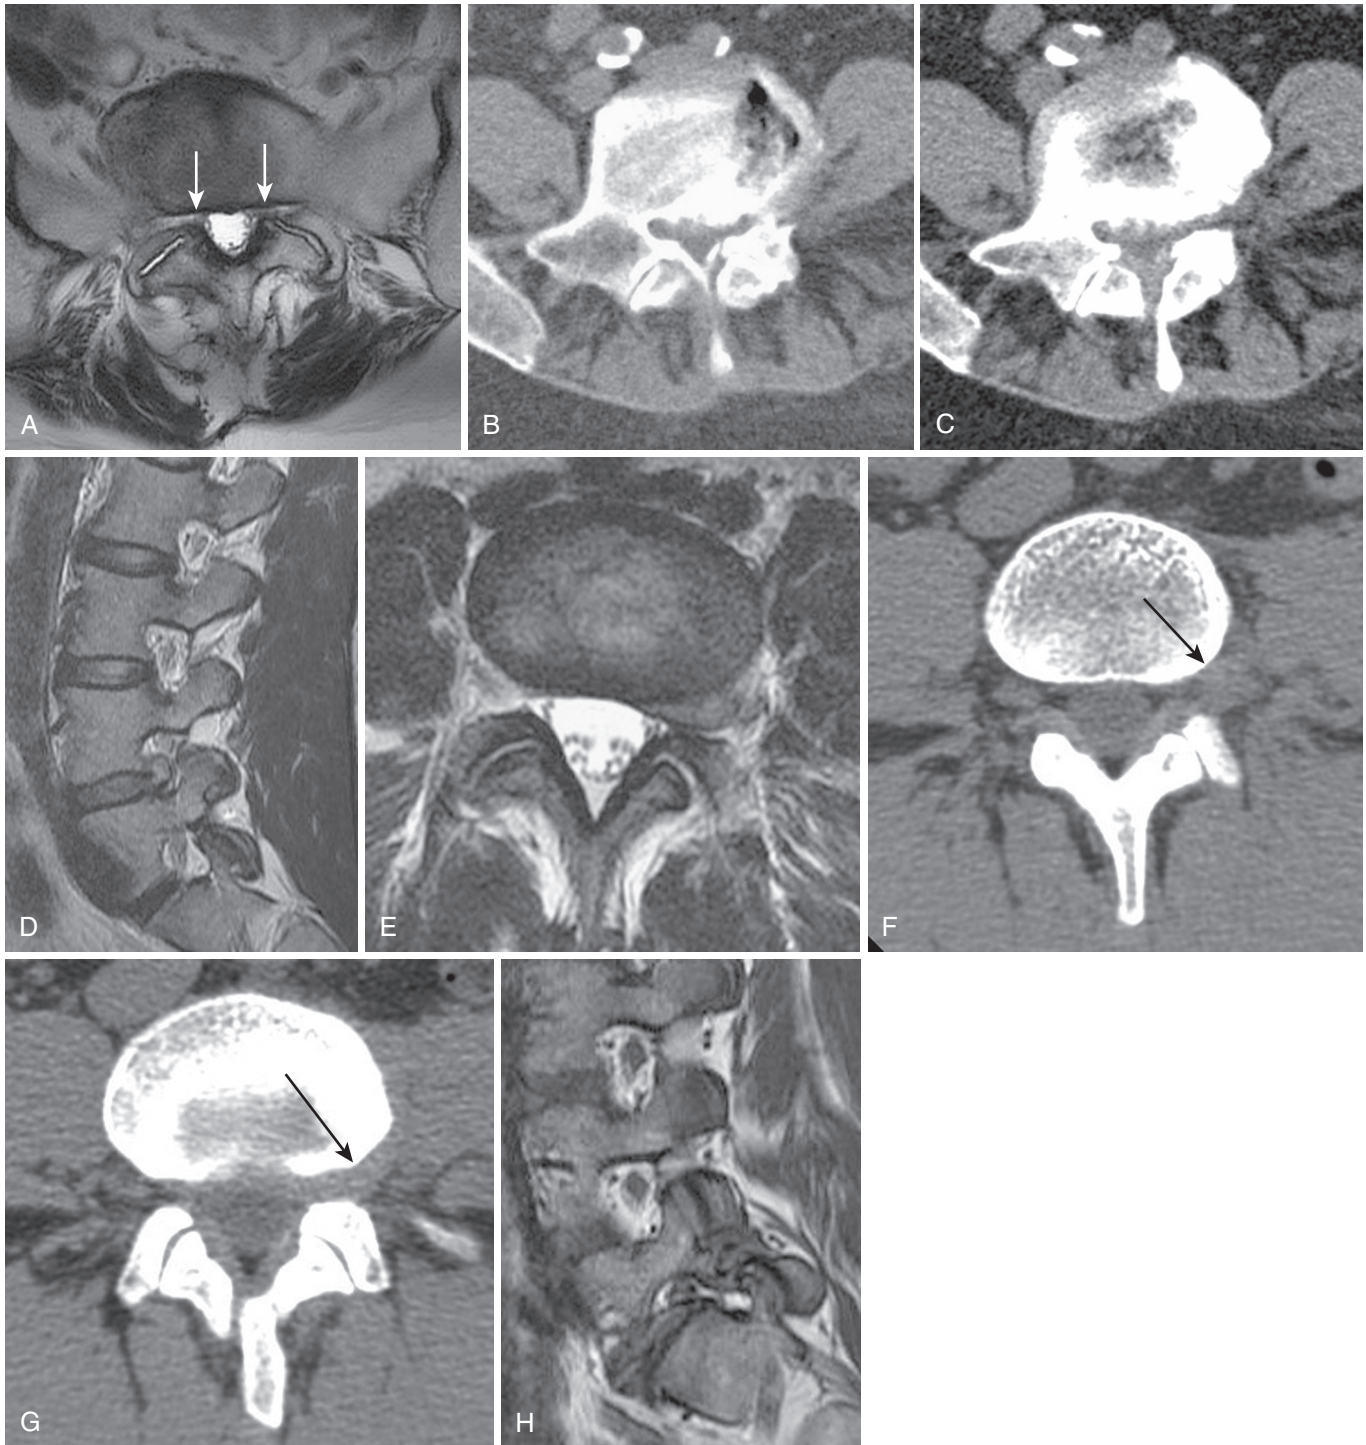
Subarticular zone (lateral recess) and foraminal compromise. Axial T2 MRI image (A) at the S1 superior end plate demonstrates a widely patent central canal, but severe bilateral subarticular zone stenosis (*arrows*) resulting from facet hypertrophy. Consecutive CT images (B, C) at the L5 pedicle level in another patient show severe central canal stenosis, but also severe subarticular zone stenosis primarily caused by end plate osteophytes. T2 sagittal and L4-5 disk axial images (D, E) in a patient with left anterior thigh pain reveal a left foraminal disk extrusion, displacing the dorsal root ganglion (DRG) superiorly and laterally. Axial CT images (F, G) in another patient with left L4 radicular pain also demonstrate a left L4 foraminal and extraforaminal extrusion (*arrows*) effacing the fat about the exiting L4 DRG and ventral ramus. A final patient with L5 spondylolysis (H) demonstrates the typical S-shaped foraminal stenosis at L5-S1 seen in this setting. Note normal foramina at L3-4 and L4-5 with abundant fat surrounding the DRG and small veins.
